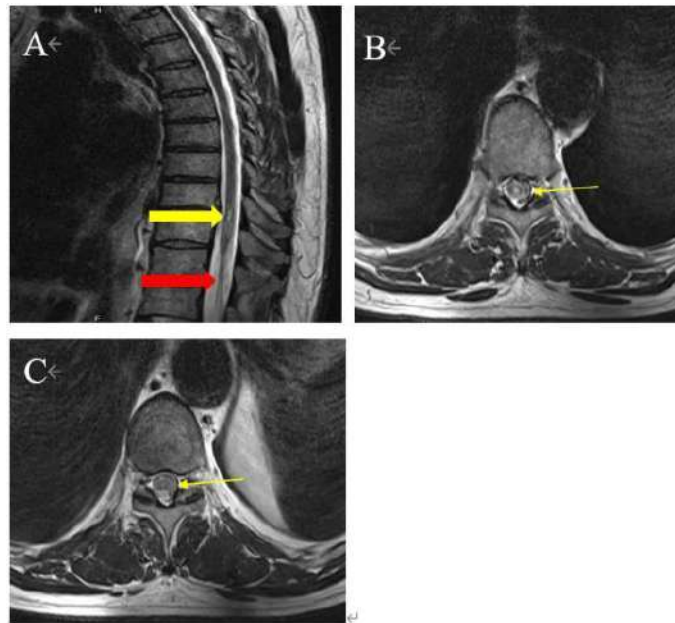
胸髓 MRI: (A) 矢状位 T2WI 像黄色箭头示 Th9/10 椎间隙水平脊髓空洞症; 红色箭头示 Th10-12 椎体水平脊髓异常信号改变. (B) 轴位 T2WI 像黄色箭头示 Th9/10 椎间隙水平脊髓空洞症. (C) 轴位 T2WI 像黄色箭头示 T11 椎体水平脊髓异常信号改变
